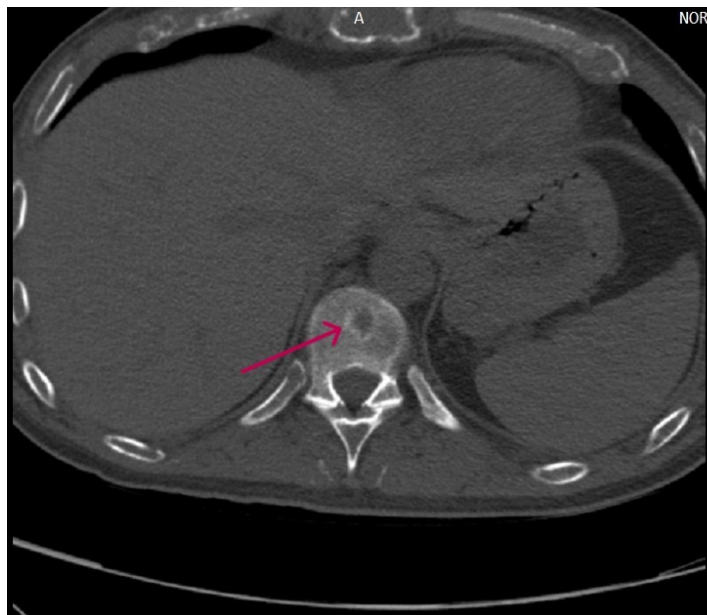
Thoraco-lumbar spinal CT scan. Axial view. Vertebral osteolytic lesion in L2 (red arrow)
